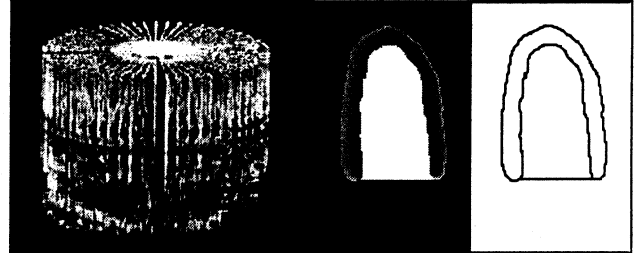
a) Radial sections of ultrasound images. b) Manual segmentation by a specialist. c) Ventricle edges extraction.
